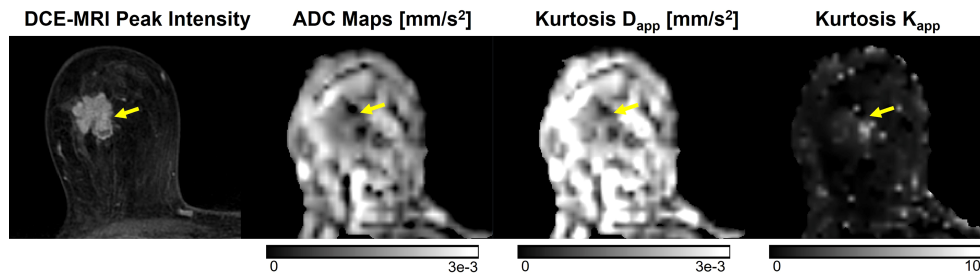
Example of DKI analysis using b-values of 0, 500, 1000, and 2000 s/mm², compared to conventional ADC images using b-values of 0 and 1000 s/mm² and DCE-MRI peak intensity subtraction (1 min 30 s post-contrast). Invasive ductal carcinoma in a 67-year-old patient is indicated by the yellow arrow. The lesion displays higher mean kurtosis (K_{app}) than surrounding healthy tissue. Images were acquired using a wide-bore 3T scanner, and mean kurtosis and diffusivity (D_{app}) were calculated as previously demonstrated (181).
